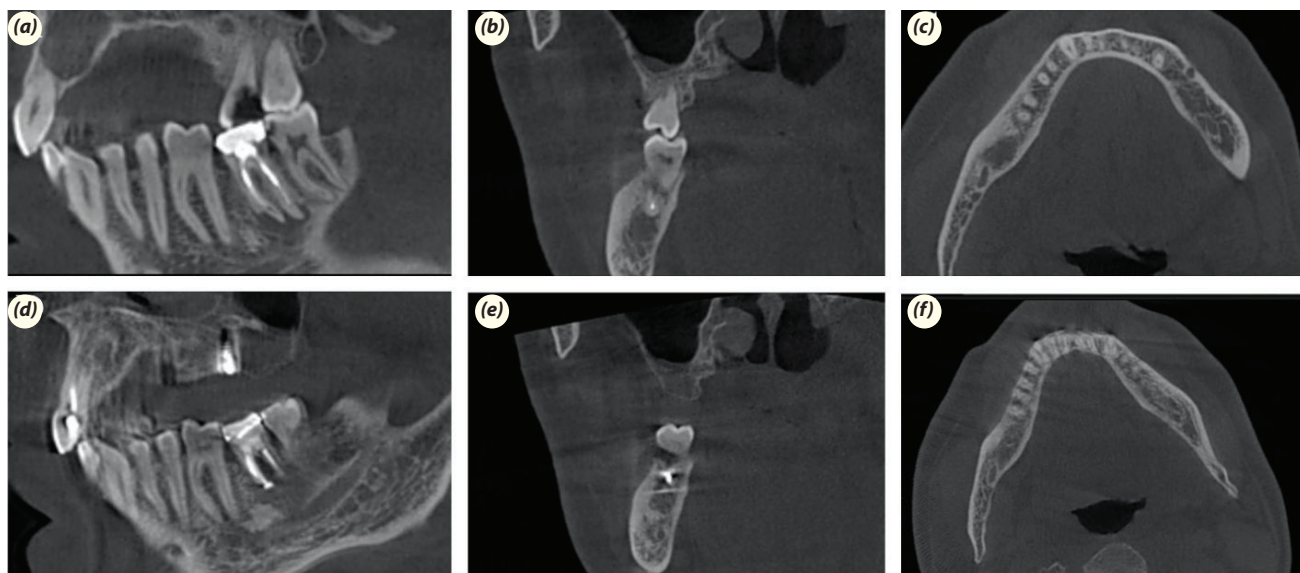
CBCT images. Baseline periapical lesion in; (a) Sagittal, (b) Coronal, and (c) Axial views. One-year follow-up in (d) Sagittal, (e) Coronal, and (f) Axial views.
